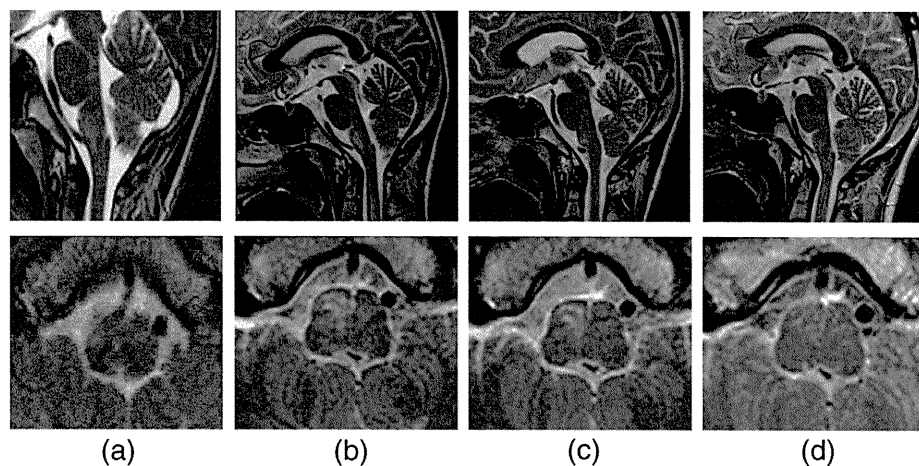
T2-weighted brain stem lesions. (a) 7 days, (b) 12 days, (c) 15 days, (d) 41 days, after neurological symptoms developed.
